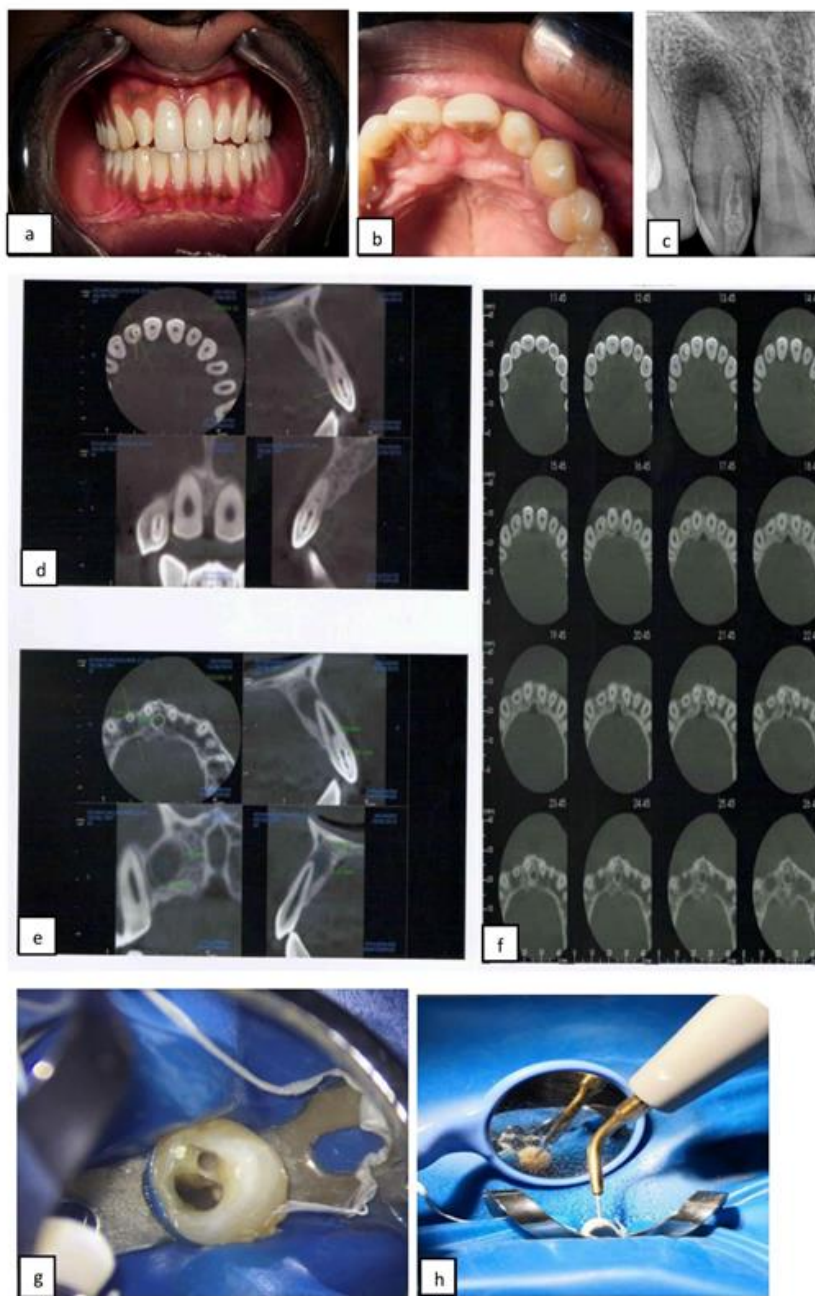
(a) Intra oral Labial view of tooth 12, (b) Palatal, (c) (d) (e) (f) cone beam computed tomography images to confirm dens invaginatus, (g) Root canal orifice and (h) Ultrasonic activation
